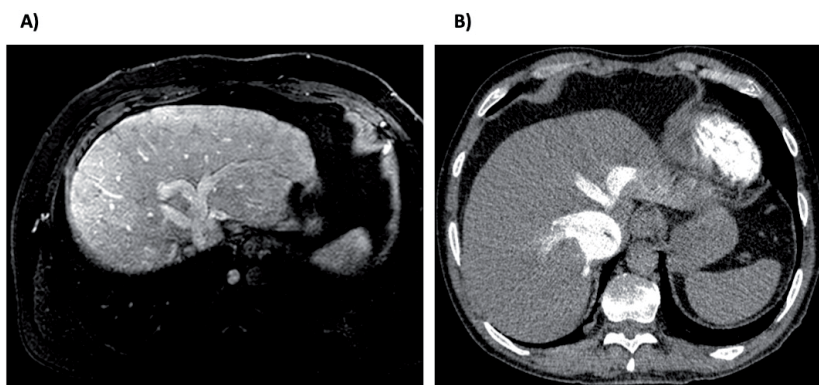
(A) Idiopathic membranous inferior vena cava obstruction in a 44-year-old man. MRI shows a mildly nodular liver with altered parenchymal perfusion and dilatation of hepatic veins. (B) Severe tricuspid regurgitation in a 49-year-old man. CT scan shows dilatation of hepatic veins and reflux of contrast into the inferior vena cava and hepatic veins.
